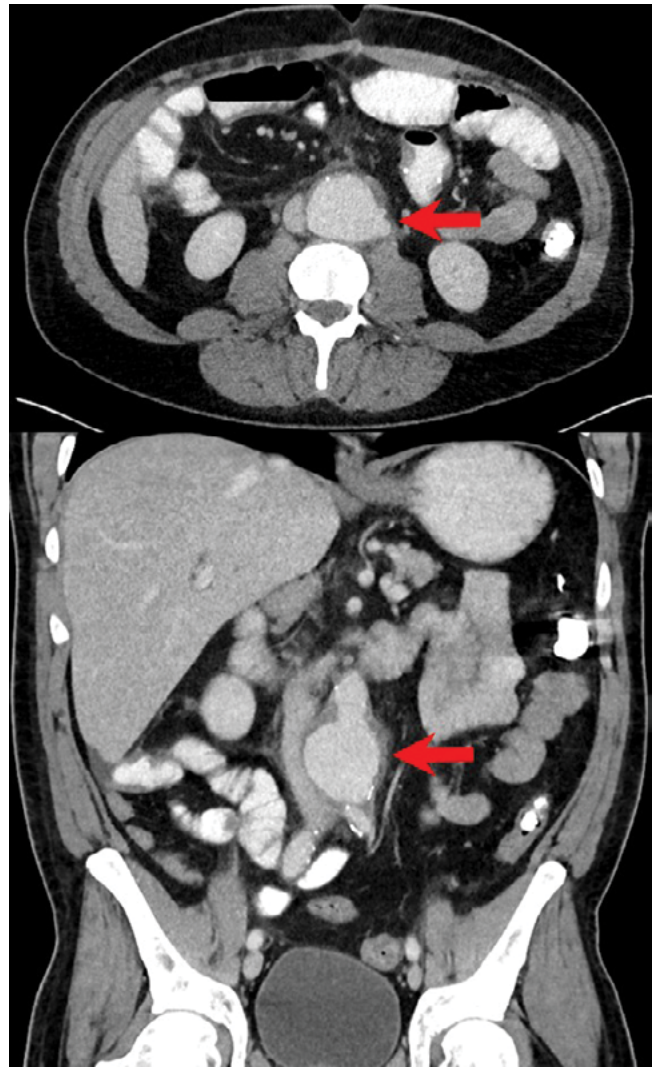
Computed tomography scan on postoperative day 15 in cross-sectional and coronal views showing aneurysmal dilation of the infrarenal aorta (arrows).
